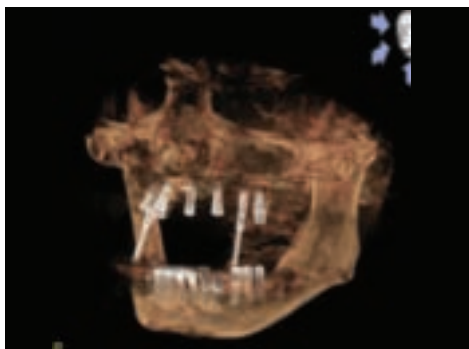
In order to verify the exact positions and the depths, CT(3D) data were taken with the depth gauges during the surgery.
